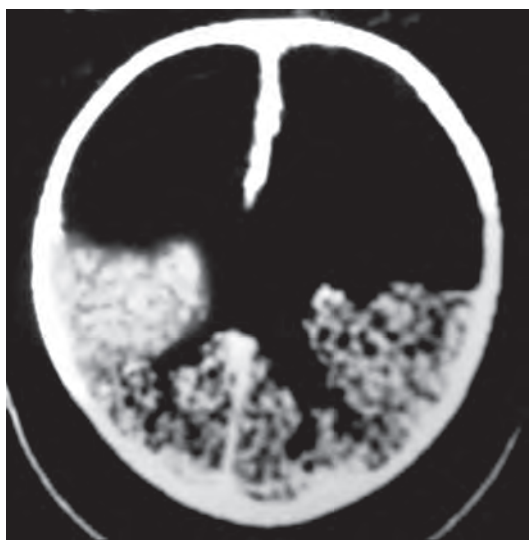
CT scan of the brain showing grossly dilated frontal horns
